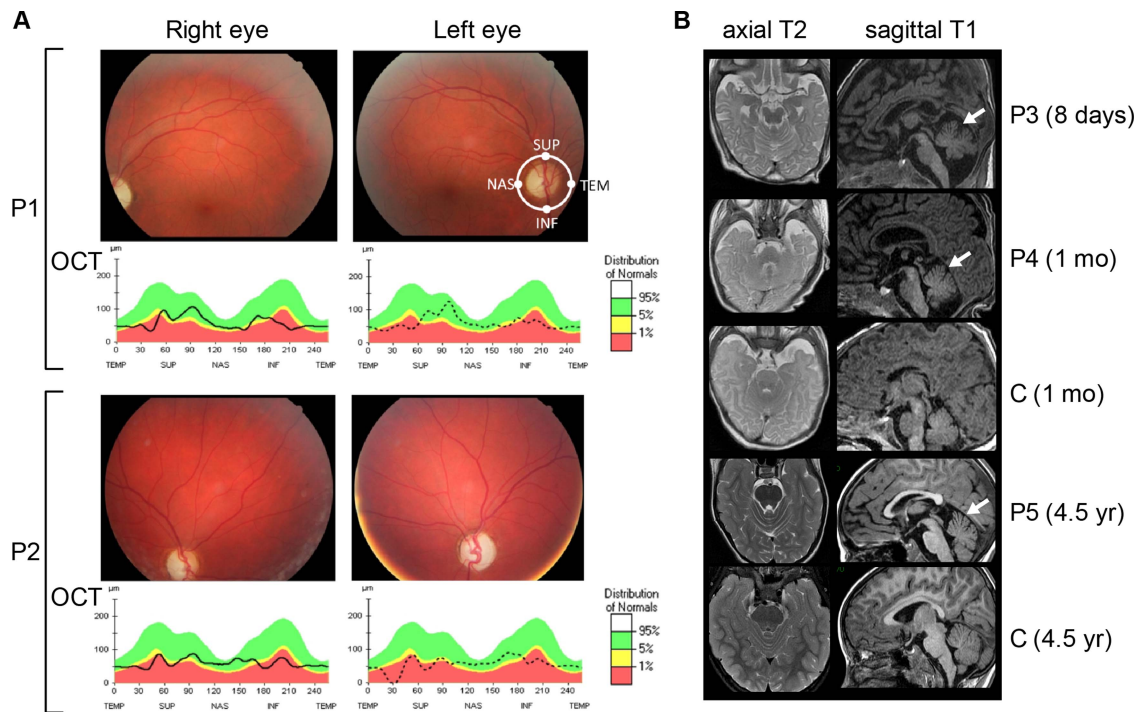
Fundus images and brain MRI. (A) Marked temporal optic atrophy in two aconitase deficient-adult siblings. Fundus images of patients P1 aged 42 years and P2 aged 37 years, show marked temporal pallor of the optic disc. Consistently, optical coherence tomography (OCT) shows marked bilateral reduction in the temporal superior and inferior retinal nerve fibre layers (RNFL) with preservation of the nasal RNFL. SUP: superior, TEM: temporal; INF: inferior; NAS: nasal. Solid and dotted OCT traces are for the right and left eyes, respectively. (B) Moderate cerebellar vermician atrophy in aconitase deficient patients. Brain MRI of three affected patients and two age-matched controls: Patient 3 and 4 aged 8 days and 1 month respectively, a 1-month-old normal control; patient 5, aged 4.5 years and a 4.5 years old control. Axial T2-weighted images (left column) and sagittal T1-weighted images (right column) showed a moderate superior atrophy of the vermis (arrows) in all affected individuals compared with age-matched controls.
